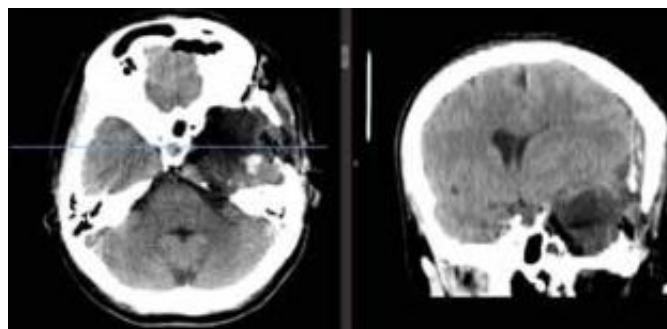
Immediate post-operative CT-scan.
